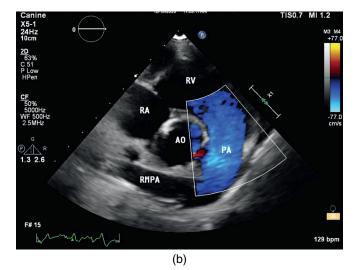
The multiple lines of Doppler sound in a color flow sector are filled with PW gates. Each gate records a positive or negative frequency shift that is displayed as a specific color. (a) When reflected sound sends back a positive frequency shift from a PW gate, meaning blood cells are moving toward the transducer, the flow at that gate is color coded in red. Here blood flow is moving up through the mitral valve on this apical 4 chamber view, and the image shows red flow moving through the mitral valve into the left ventricle. (b) When reflected sound sends back a negative frequency shift from a PW gate, meaning blood cells are moving away from the transducer, the flow at that gate is color coded in blue. Here blood flow is moving down into the pulmonary artery on this right transverse view, and the image shows blue flow moving from the right ventricle into the pulmonary artery.
